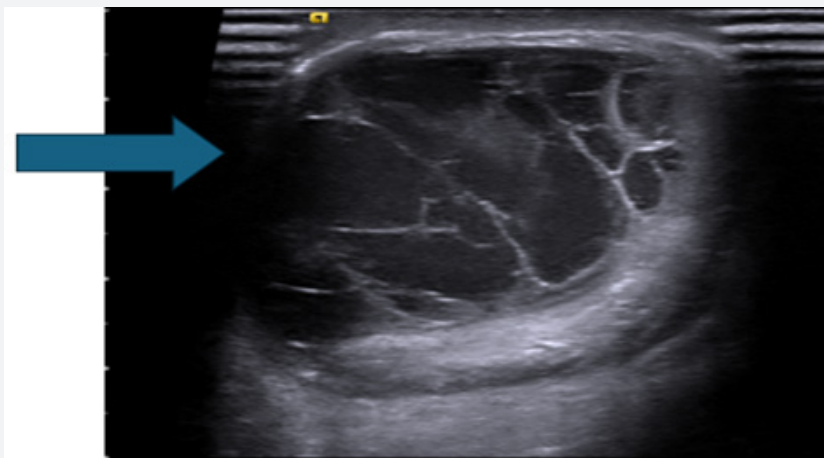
U/S Doppler epididymo-orchitis.
